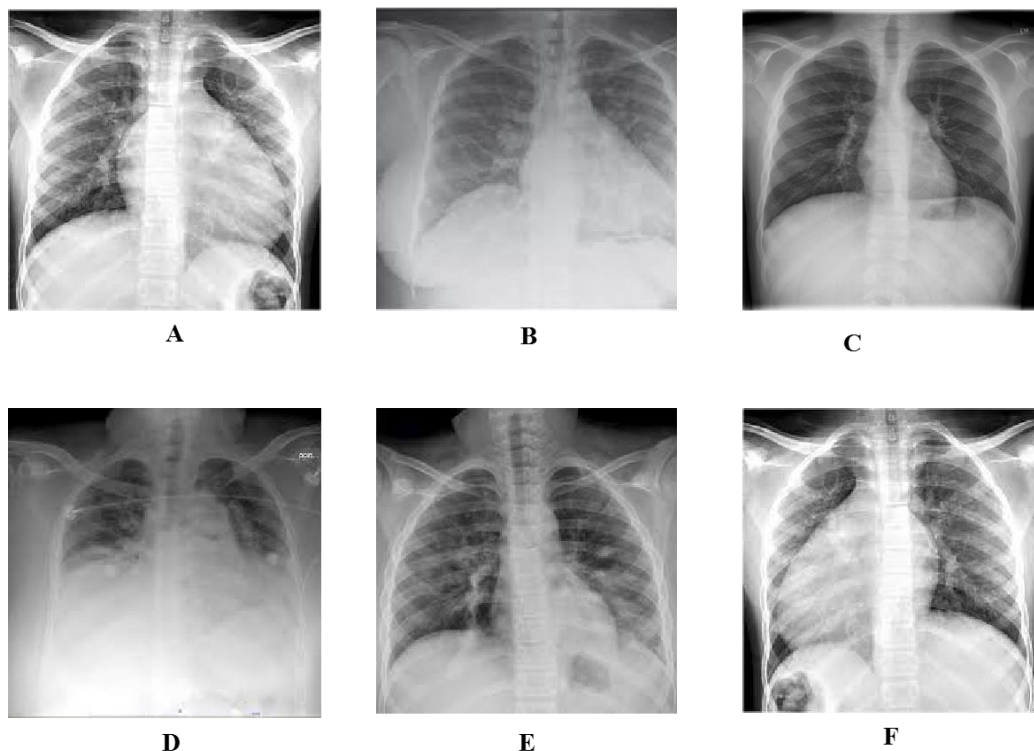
Chest radiographic images of six sickle cell disease patients who were infected with COVID-19 and died.
